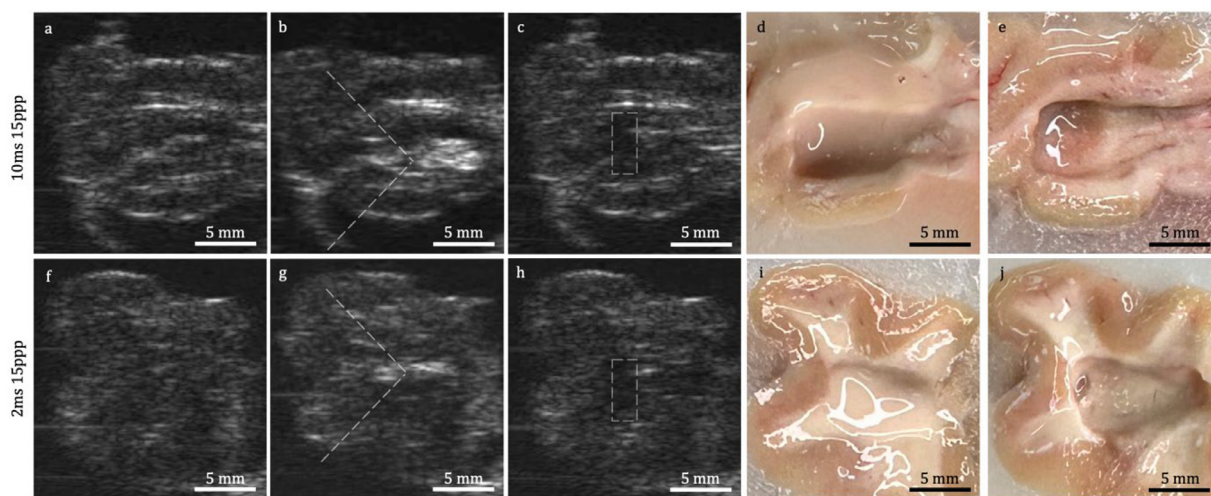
B-mode images and gross photographs after bisection of the brain samples treated with (10 ms 15 ppp) (top row) and (2 ms 15 ppp) (bottom row). B-mode images before (a, f), during (b, g), and after (c, h) the treatment. Dashed lines in (b, g) indicate the geometry of the boiling histotripsy (BH) beam. Dashed boxes in (c, h) outline the target area (i.e., targeted grid + 1 mm laterally and axially). Gross photographs after lesion bisection before (d, i) and after (e, j) rinsing the lesion with phosphate-buffered saline. Scale bars, 5 mm. High-intensity focused ultrasound (HIFU) incident from the left.
